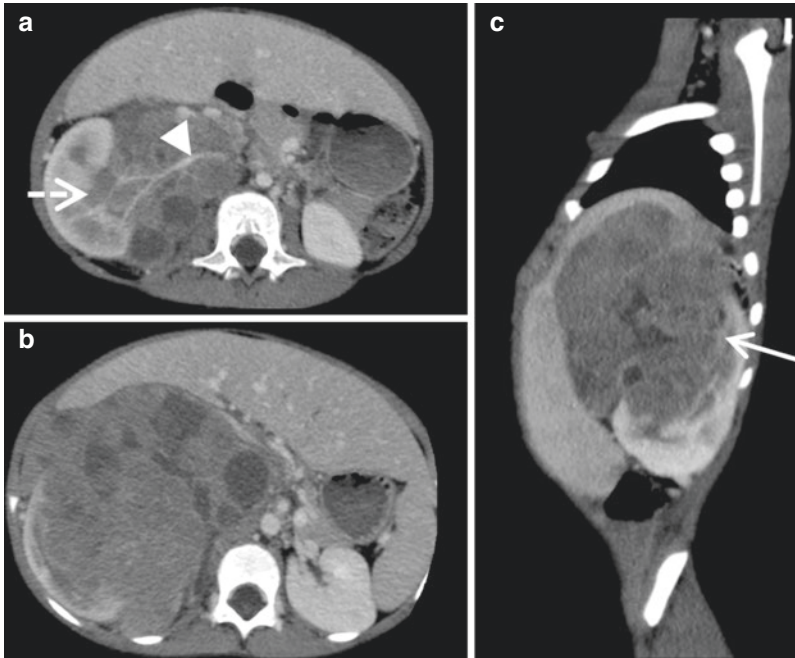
A 4-year-old girl with localized right adrenal neuroblastoma (MYCN amplified, INSS stage 3, INRGSS L2). Contrast-enhanced transverse CT scan (a, b) and MPR sagittal views (c). The tumour demonstrates moderate and heterogeneous enhancement with necrotic low densities. The mass infiltrates the upper pole (arrow) and the hilum (dotted arrow) of the right kidney and encases the renal pedicle (arrowhead)
